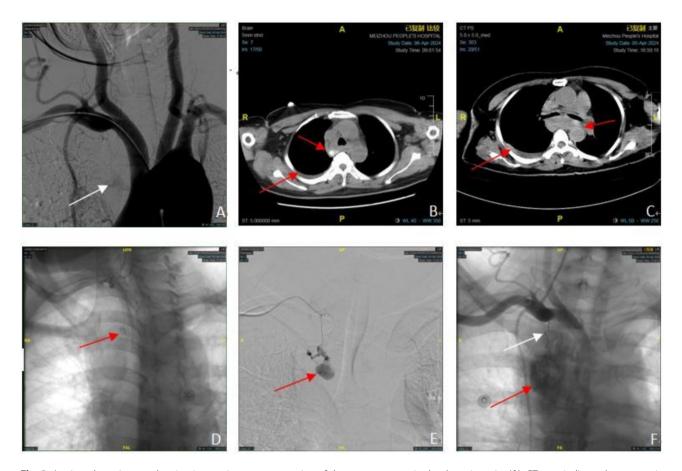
Aortic arch angiogram showing inconspicuous extravasation of the contrast agent in the thoracic cavity (A). CT scan indicates hematoma in the middle mediastinum and right thoracic cavity (B, C). Angiograms show the perforation (red arrow) before (D, E) and after (F) embolization using microcoils (white arrow)
